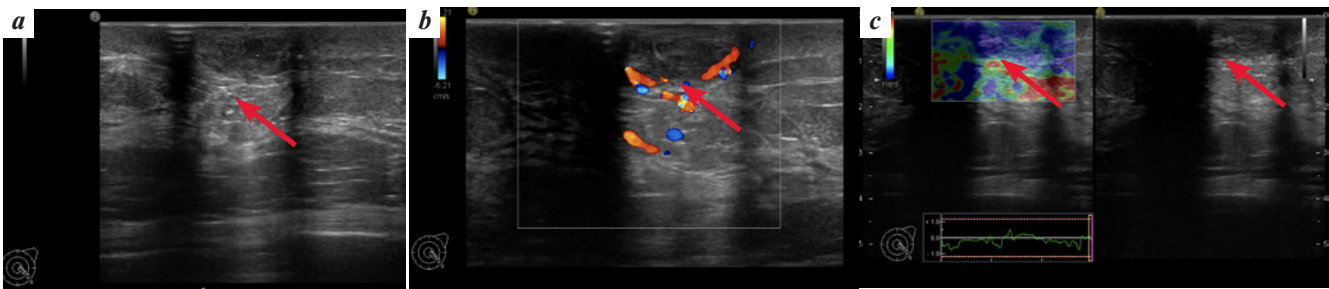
Tumor sonography: a hypoechoic heterogeneous formation with a smooth and unclear contour (a); blood flow is detected in the lower edge of the tumor (b). Tumor (arrow) elastography (c)
